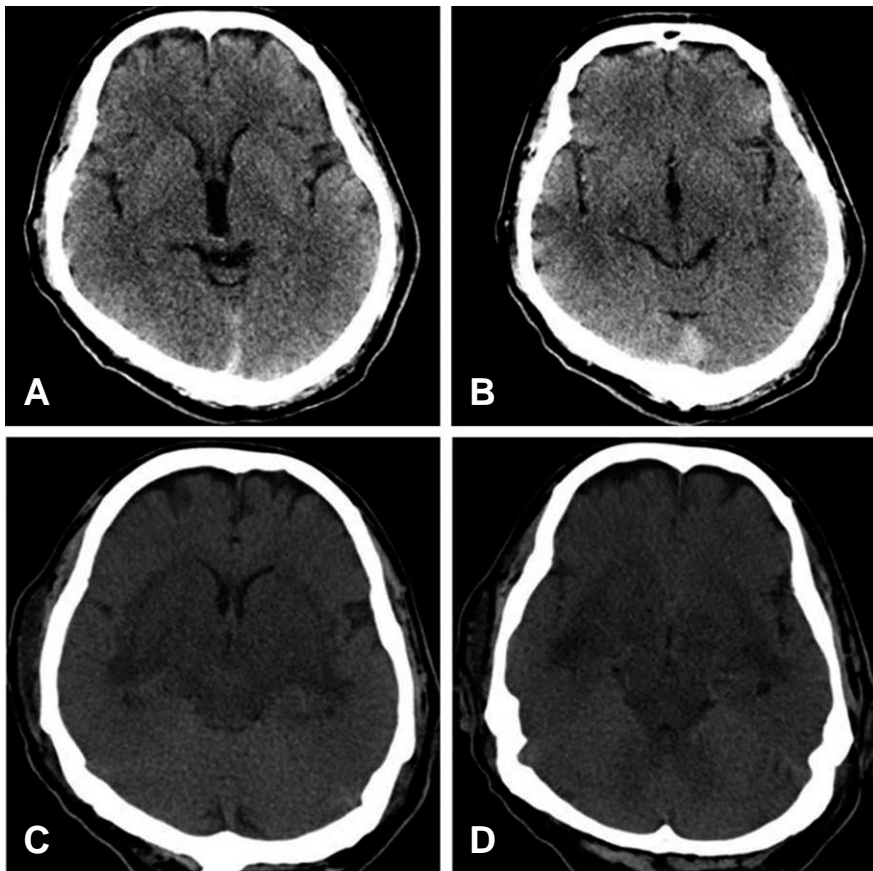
(A, B) Initial brain CT image. (C, D) Follow-up brain CT 3 days after presentation. The images show brain swelling, a low-density lesion of bilateral deep gray matter and brain stem, and sulcus effacement.
